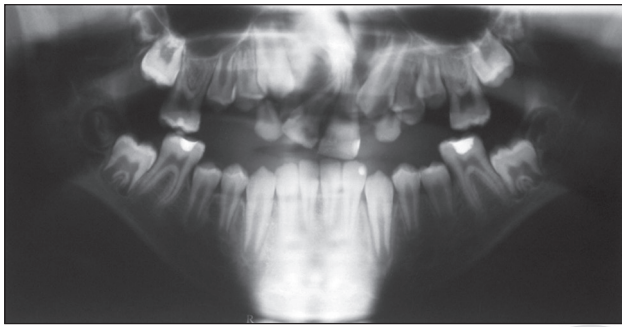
Orthopantomogram (unilateral CLP on the right side)
